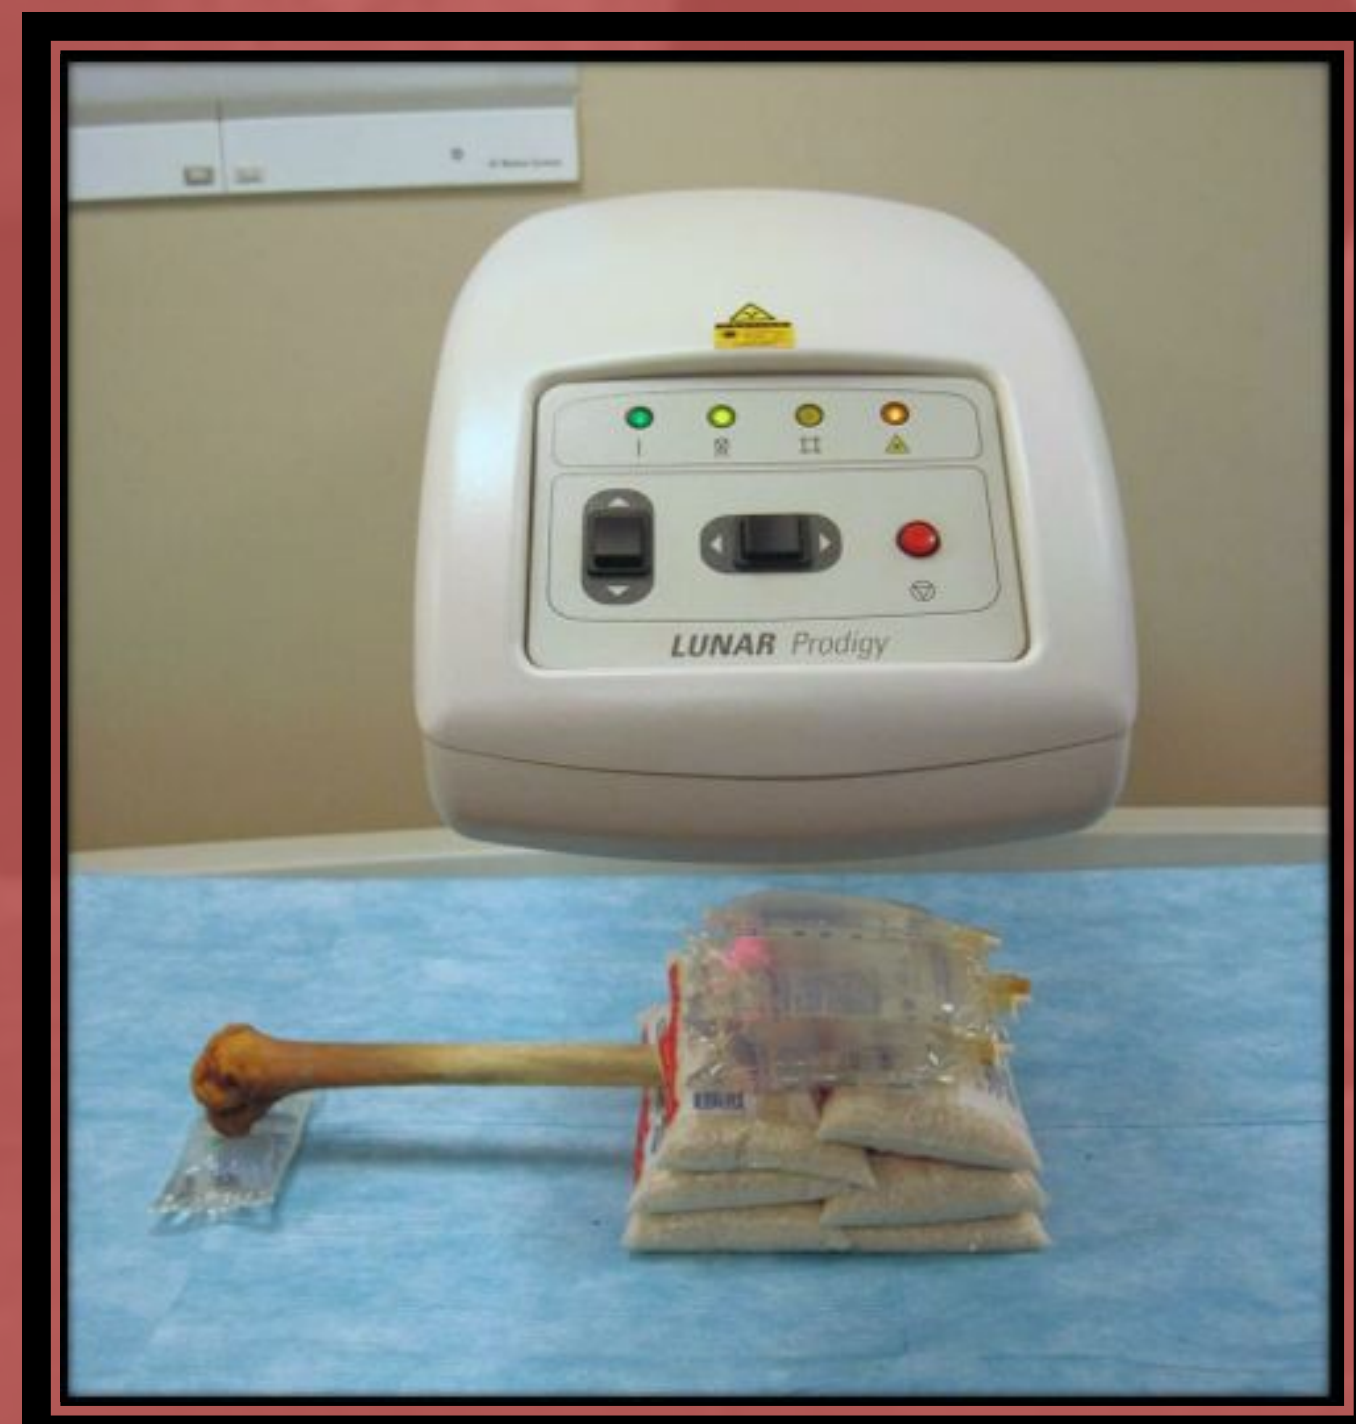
Femur in the process of being scanned by a Dual-Energy X-Ray Absorptiometry Instrument. Photo by Alexis Goots.
